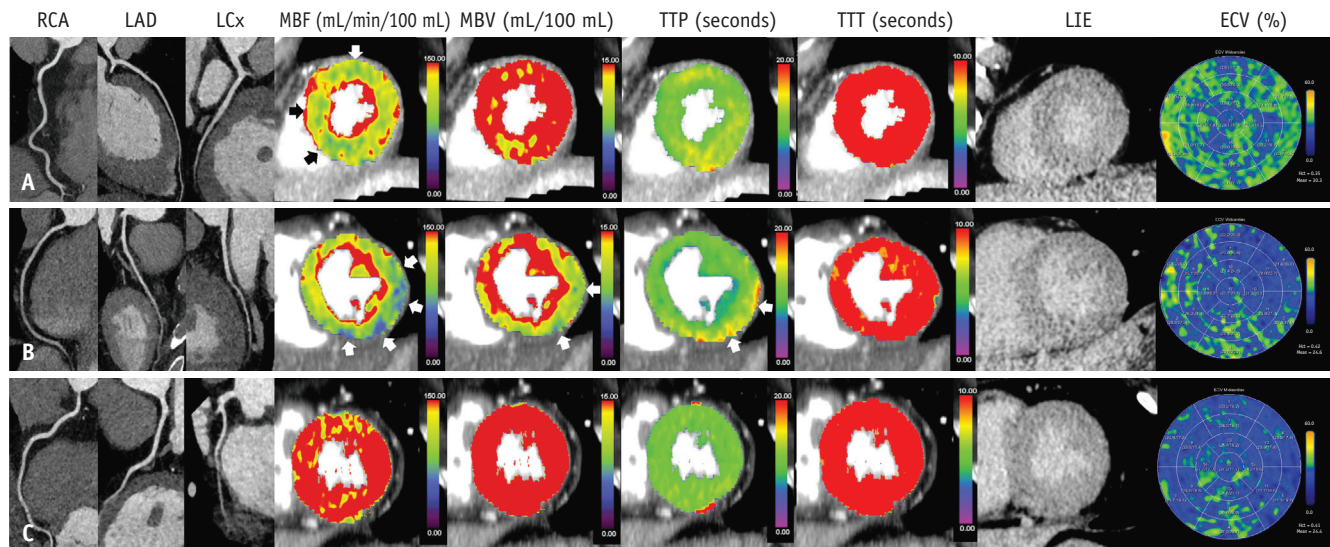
Quantitative analysis of myocardial perfusion and interstitial fibrosis in patients with and without diabetes without obstructive stenosis. A: Representative case of a 65-year-old diabetic female with exertional chest pain. CCTA revealed mild atherosclerosis of the coronary arteries without obstructive stenosis. MBF diffusely decreased (ranging from 77.6 mL/min/100 mL to 95.9 mL/min/100 mL) (white and black arrows) whereas ECV diffusely increased (global ECV = 30.3%), indicating the presence of microvascular ischemia and interstitial fibrosis. LIE did not show evident enhancement. B: Representative case of a 63-year-old male patient with diabetes and exertional chest pain. CCTA revealed normal coronary vasculature. MBF of the basal lateral and inferior segments was significantly reduced (ranging from 69.0 mL/min/100 mL to 75.3 mL/min/100 mL) (white arrows) whereas ECV was within the normal range (global ECV = 24.6%), indicating the presence of microvascular ischemia and absence of interstitial fibrosis. LIE did not show evident enhancement. C: Representative case of a 60-year-old male patient with diabetes but without angina symptoms. MBF (mean MBF = 175.7 mL/min/100 mL) and ECV (global ECV = 24.4%) were within the normal range, indicating the absence of microvascular ischemia and interstitial fibrosis. LIE did not show evident enhancement. RCA = right coronary artery, LAD = left anterior descending artery, LCx = left circumflex artery, MBF = myocardial blood flow, MBV = myocardial blood volume, TTP = time to peak, TTT = tissue transit time, LIE = late iodine enhancement, ECV = extracellular volume, CCTA = coronary computed tomography angiography, Hct = hematocrit
